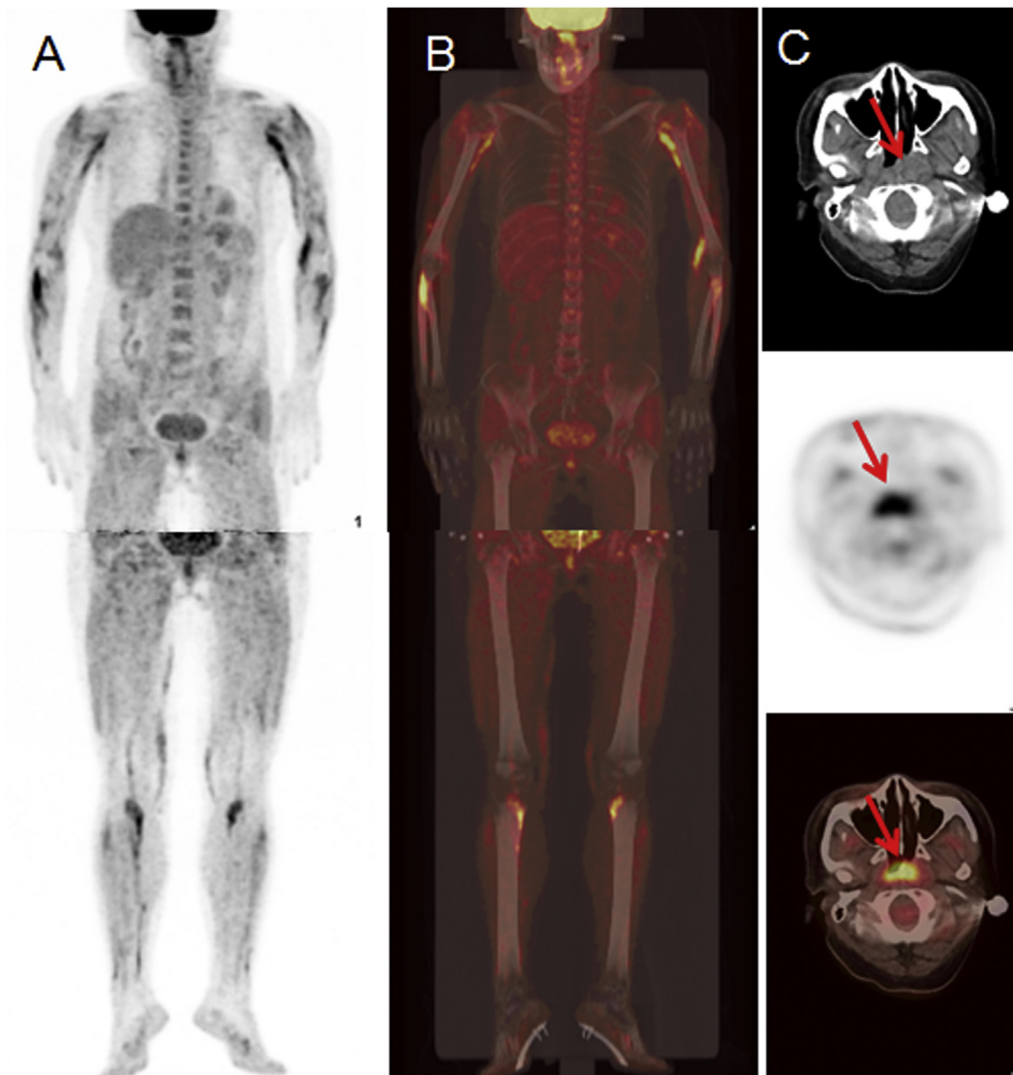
A 41-year-old female was diagnosed with dermatomyositis (Table 1, No 15). A-B, PET/CT images showed increased ^{18}F -FDG uptake in muscles, especially in limb muscles. C, Increased ^{18}F -FDG uptake was seen in the left nasopharynx with nasopharyngeal wall thickening, nasopharyngeal carcinoma was suspected (arrow). The pathological result showed it was nasopharyngeal carcinoma.
